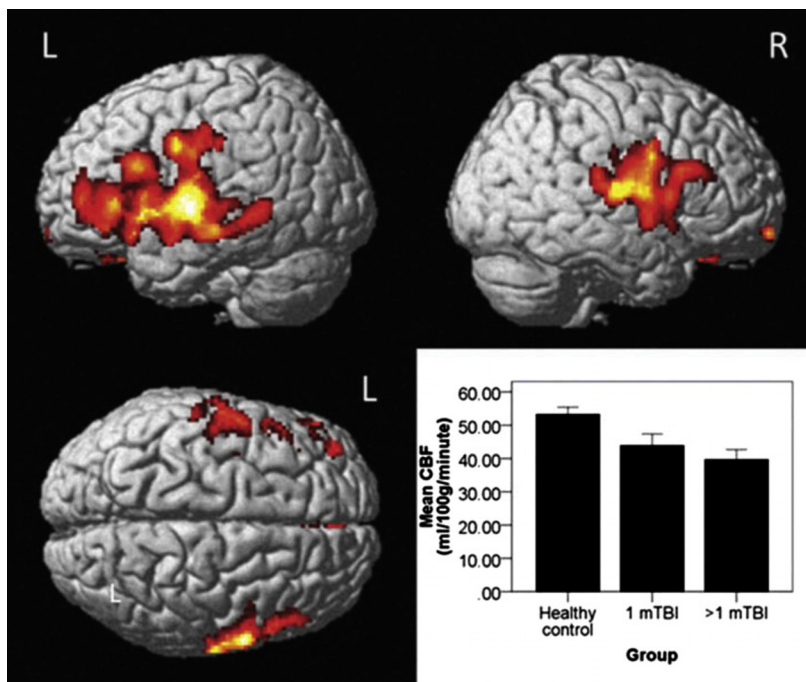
Results of arterial spin labeling analysis in mild traumatic brain injury (mTBI) patients from [Wang et al. \(2015\)](#). When compared to a healthy control population, pediatric sports/recreation mTBI subjects demonstrated lower cerebral blood flow (CBF) in the bilateral frontotemporal regions despite normal structural imaging. (Reproduced from Wang Y, West JD, Bailey JN, et al. (2015) Decreased cerebral blood flow in chronic pediatric mild TBI: an MRI perfusion study. *Dev Neuropsychol* 40: 40–44.)
